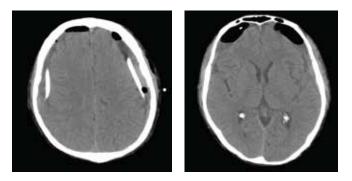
CT brain images showing the patient post bilateral burr-hole decompression. It shows marked reduction in the subdural haemorrhage and resolution of previous mass effect.
